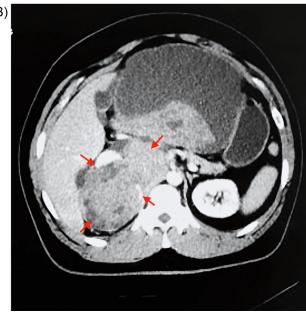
(A and B): Coronal (frontal) and axial (transverse) views of the CT scan of the patient's abdomen and pelvis disclosed a discernible left adrenal gland, while the right adrenal gland remained obscured by the mass (red arrows).
